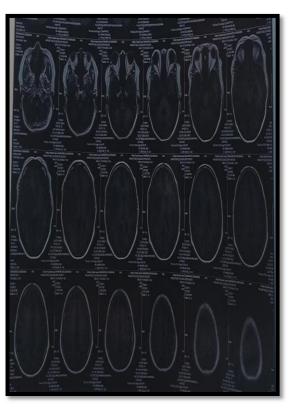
MRI Image Showed Figure 2. MRI Image Showed mild heterogeneously enhancing, predominantly surrounding edema in the right T2 hyperintense focal mass lesion dated perisylvian frontotemporal region. May 20, 2022
